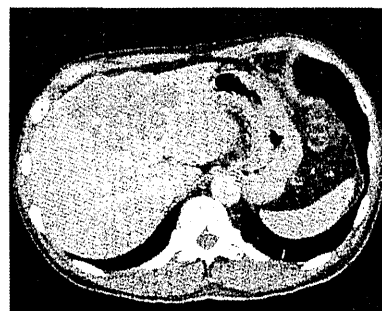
Abdominal computed tomography scan with late phase contrast enhancement showing a low density mass lesion of 9-cm diameter in the liver.
